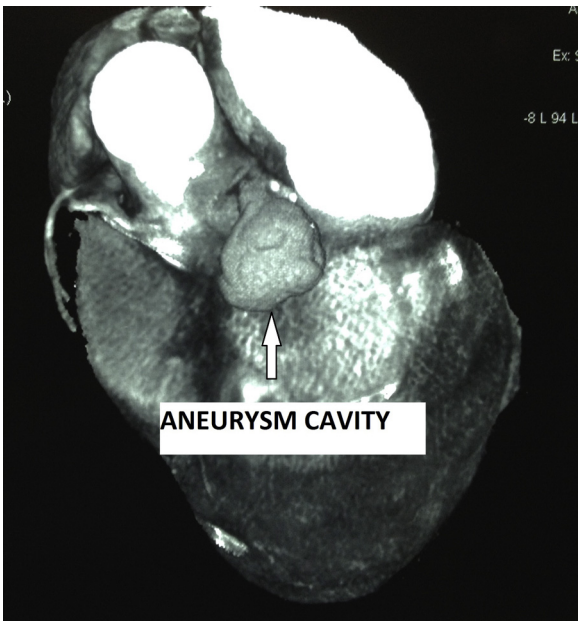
CT angiography showing large aneurysmal cavity with narrow neck.
